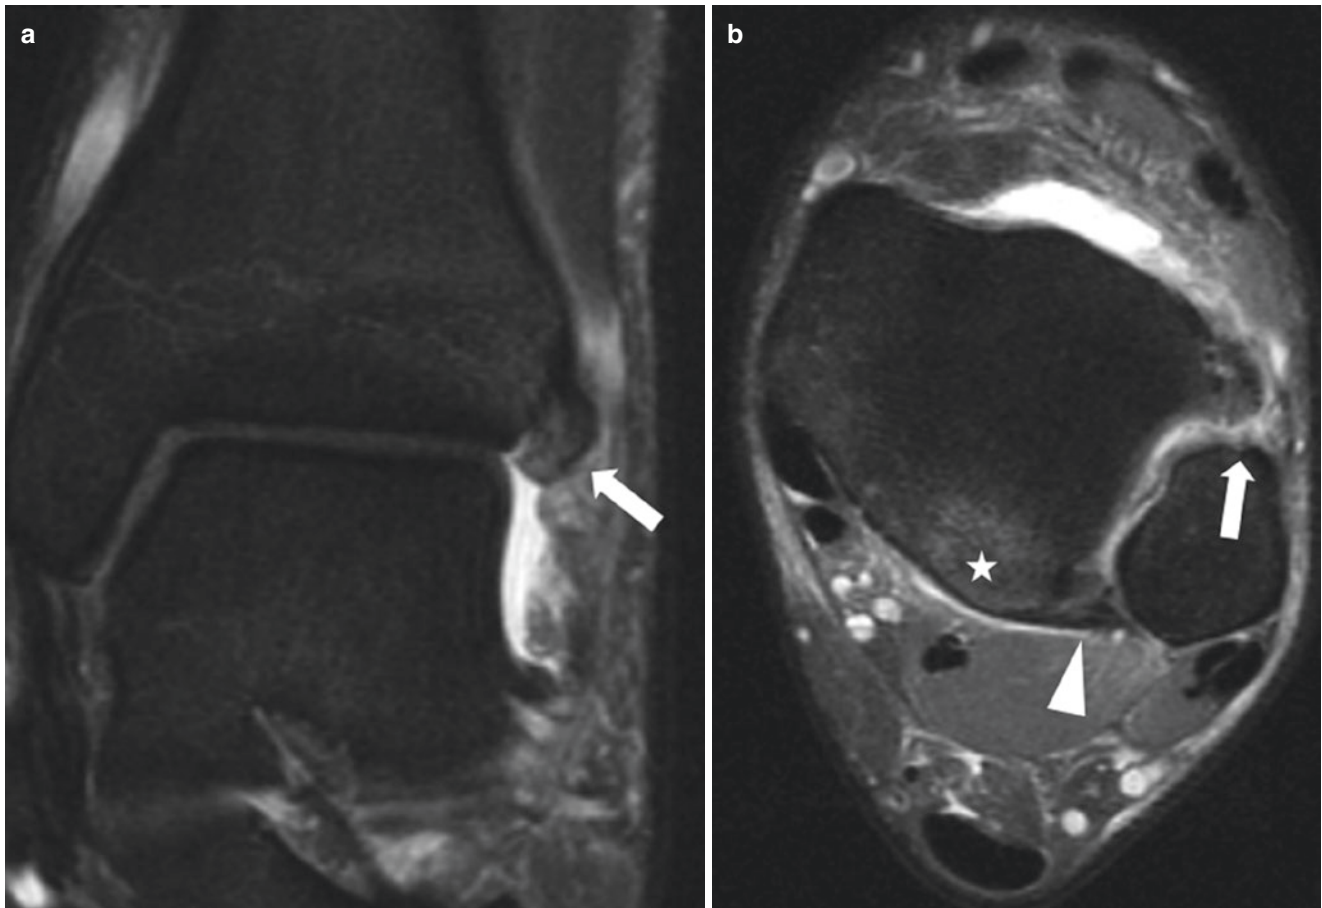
Anterior syndesmotic tear. Coronal (a) and axial (b) fat-suppressed intermediate weighted MR images of the left ankle demonstrate a tear of the anteroinferior tibiofibular ligament at its fibular
